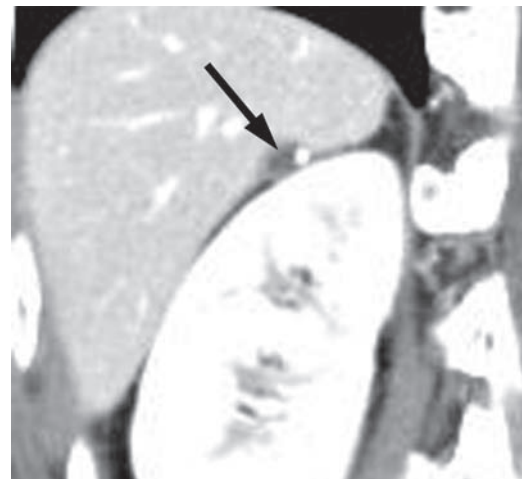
Pseudolipoma of the Glisson capsule in a 36-year-old woman. Portal venous phase coronal reformatted CT image shows a fatty mass with peripheral calcification (arrow) at the posterior notch of the liver.
